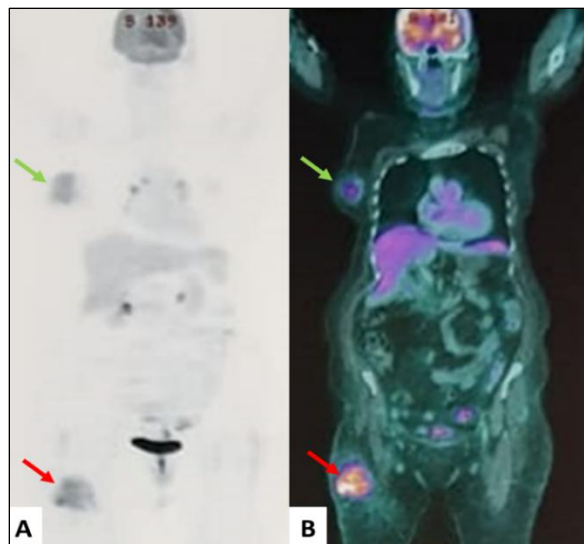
PET CT Imaging.
